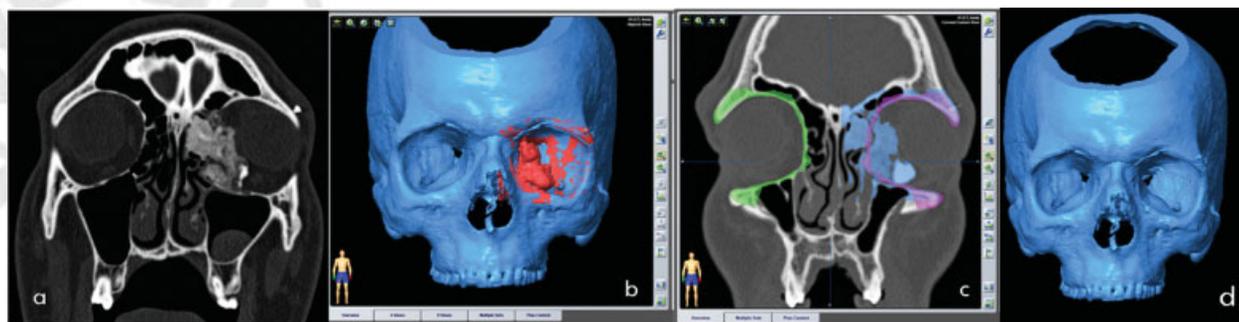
(a) CT scan showed an expansive mass, (b) orbital tumor, (c) the mirroring process, (d) to virtually “subtract” the endo-orbital pathology using PlastiCAD (3Diemme, Cantù, Italy).
